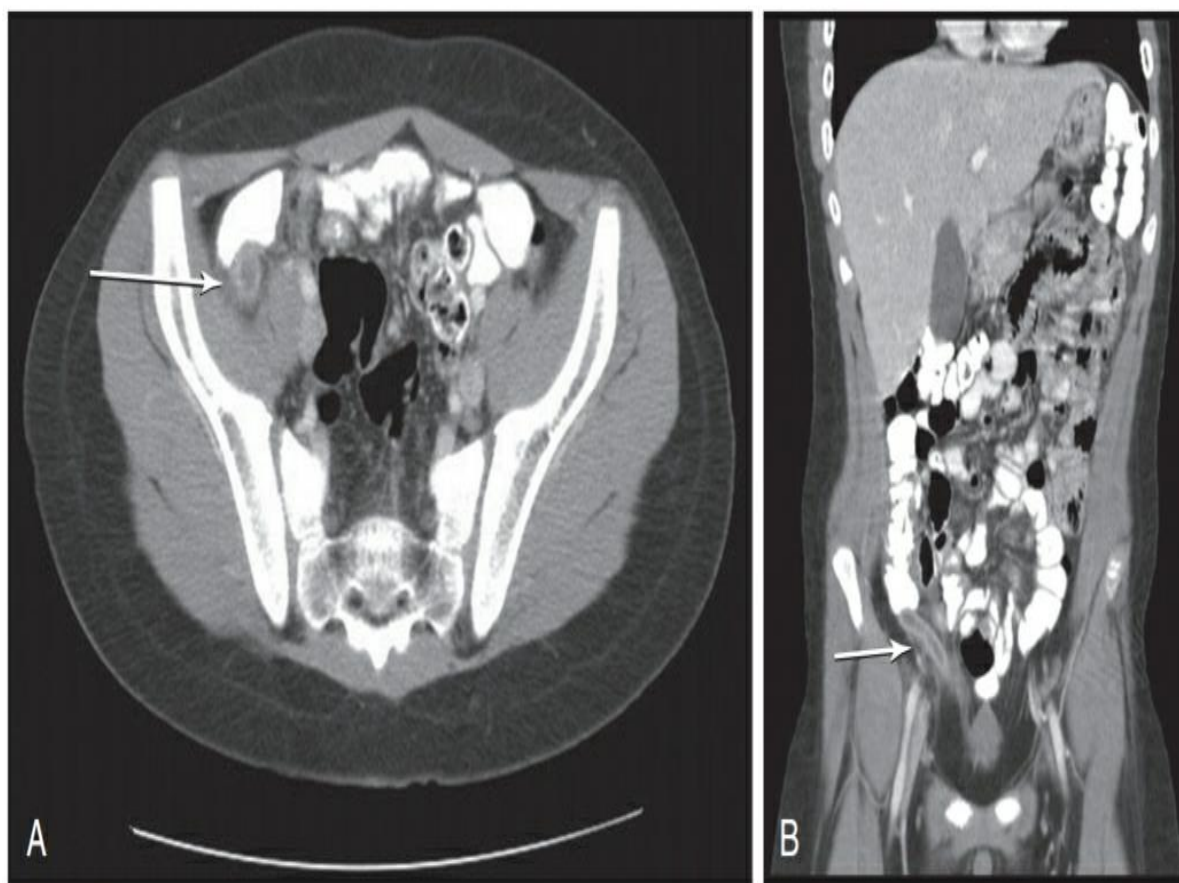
CT scan of the abdomen demonstrating classic findings of acute appendicitis. A, Sagittal view with *arrow* demonstrating a thickened, inflamed, and fluid-filled appendix (target sign). B, Coronal view of same patient. The *arrow* points to the thickened, elongated appendix with periappendiceal fat stranding and fluid around the appendiceal tip.
